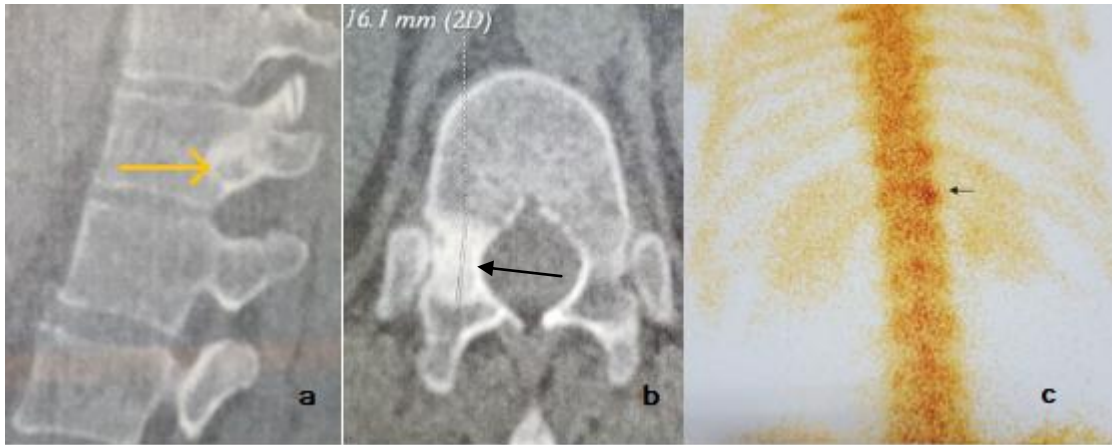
Thoracic spine CT scan (A&B) show a right pedicular small osteolytic lesion surrounded by a sclerotic (arrow) reaction. Bone scan (C) shows hyper-fixation of the right T12 vertebra region (arrow)
